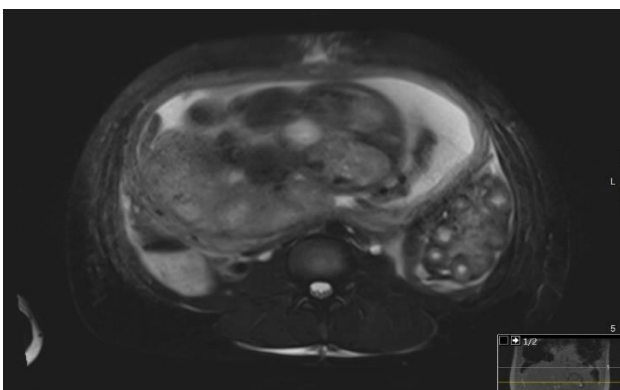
MRI image of enlarged left ovary with multiple peripheral follicles.
